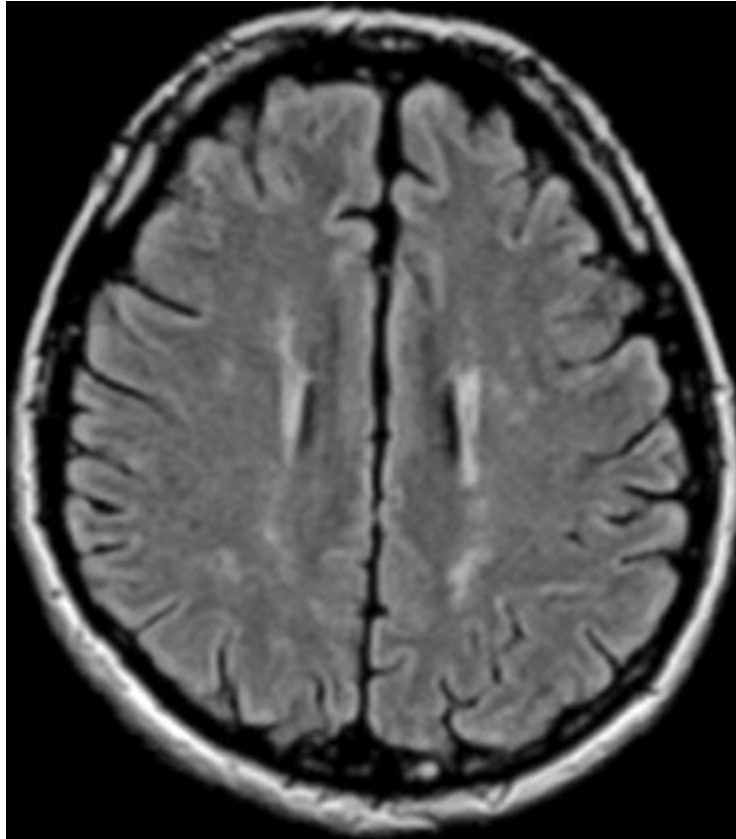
White matter lesions in the cerebral hemispheres in Fabry disease: axial FLAIR MRI section (Reproduced with permission from Ginsberg et al. [23])
